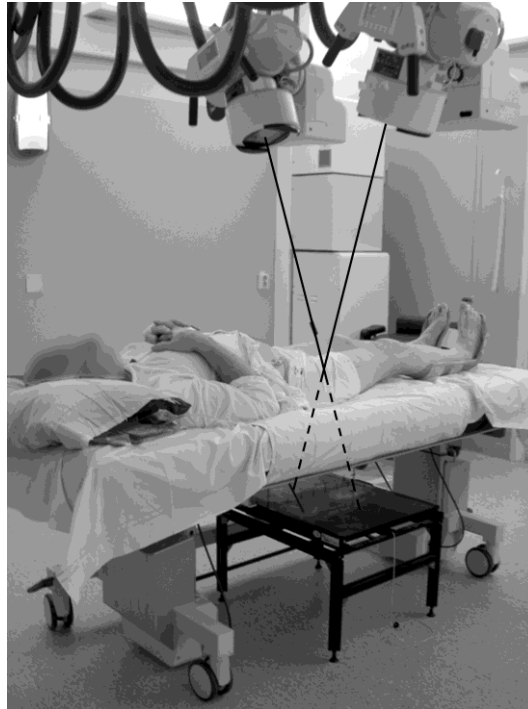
Patient in position for RSA examination with the two X-ray tubes above and the calibration cage beneath the patient
